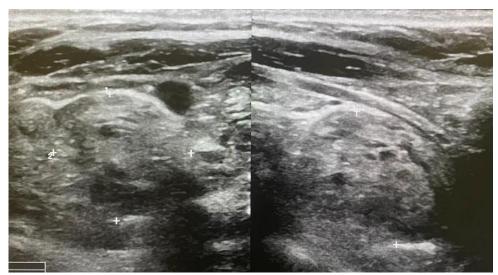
Thyroid Ultrasound
